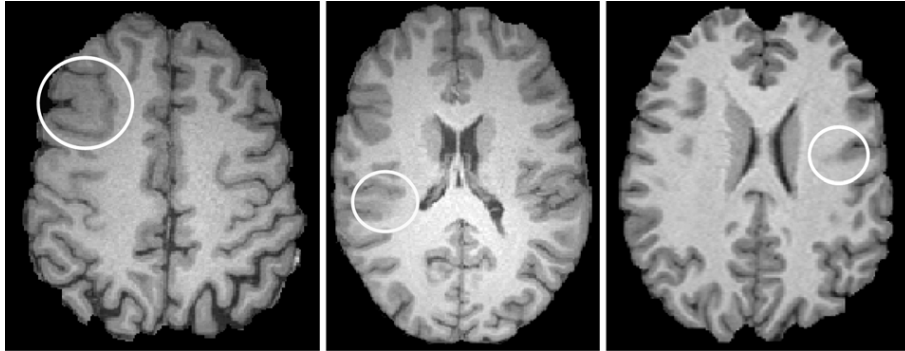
Three examples of T_1 -W MRI with FCD lesions. The lesions are indicated with a circle. They are characterized by increased cortical thickness and blurring of the cortical gray matter and white matter border.
